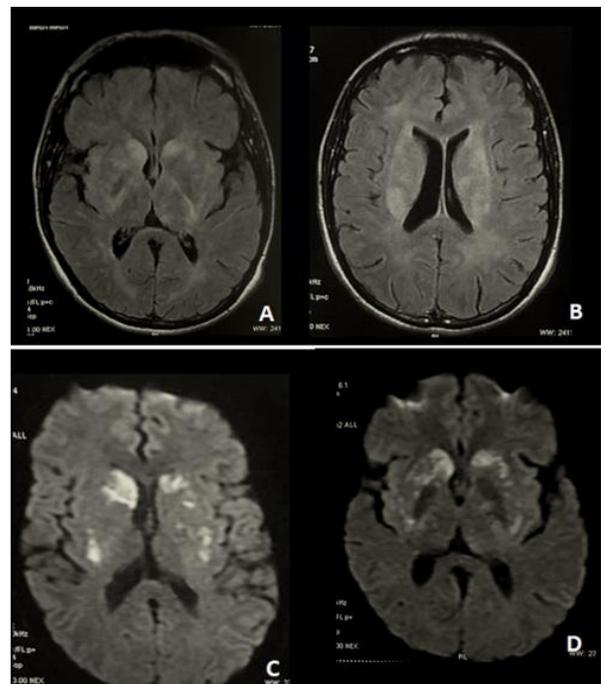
Cryptococcosis with acute ischemic lesions :FLAIR (A,B) and diffusion (C,D) axial sections: multiple bilateral and asymmetric FLAIR hypersignal patchy signal anomalies with diffusion restriction in the basal ganglia and external capsule in relation to ischaemic lesions
